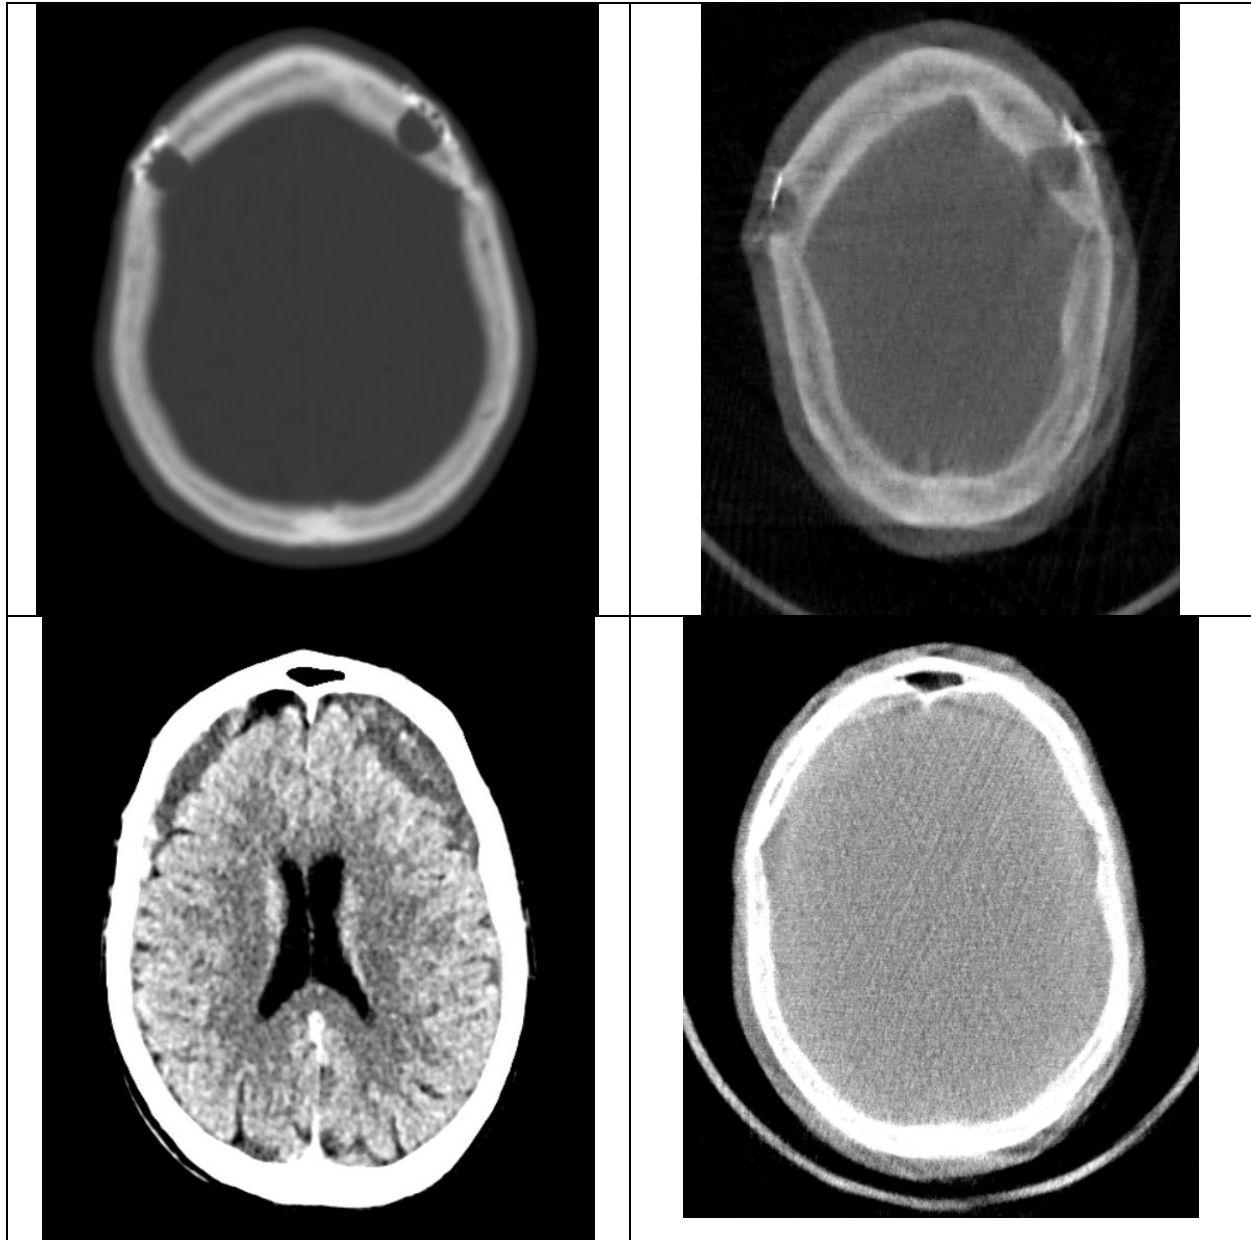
Bone and brain reformats (top / bottom) of a conventional CT and the sHCT (left / right). Osseous structures are relatively clearly defined in the bone reformats, but imaging of the brain parenchyma remains limited.
